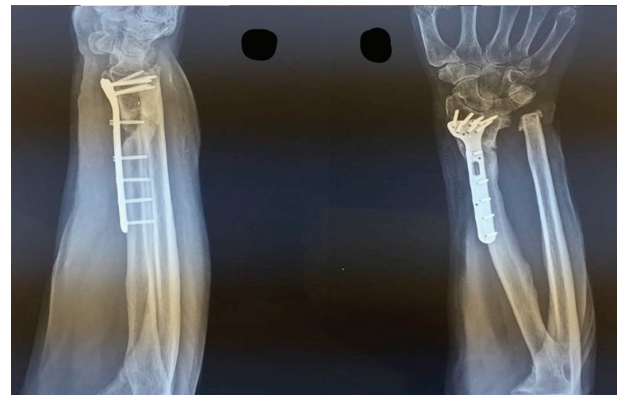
(Case 3). A) Preop AP X-ray; B) 3b Preop. LL X-rayFigure 10 (Case 3). 3 months post-op X-ray.Figure 8 (Case 3): A) Preop. clinical dorsal view; B) Preop. clinical lateral view
